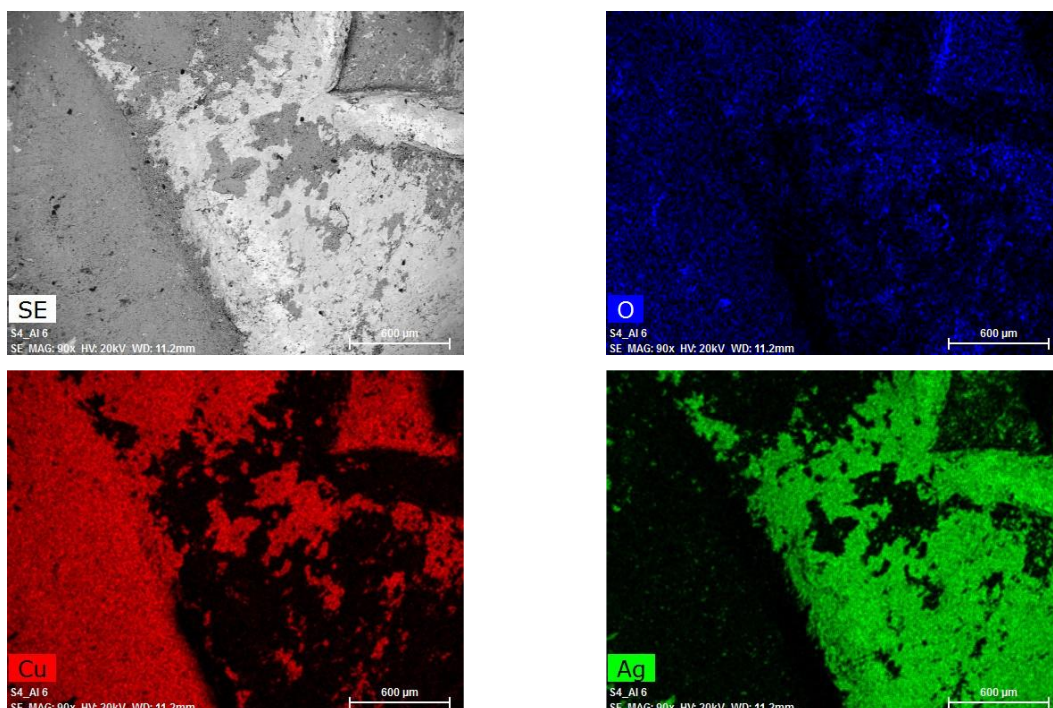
SE image and X-ray maps on the surface of antoninianus no. A48 obtained by SEM-EDX.
